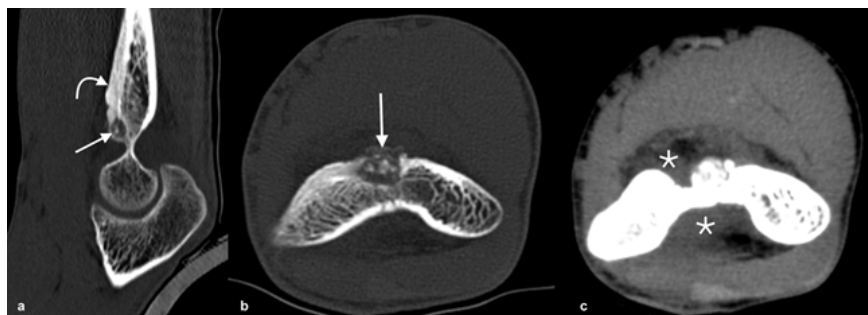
CT of the elbow. Sagittal reconstruction (a) demonstrates the presence of the radiolucent nidus in the coronoid fossa (arrow) and prominent periosteal reaction (curved arrow). Axial CT image with bone window (b) show the 15-mm diameter radiolucent nidus (arrow) that contains a calcified centre. On axial CT image with soft tissue window (c) mild joint effusion is identified.
